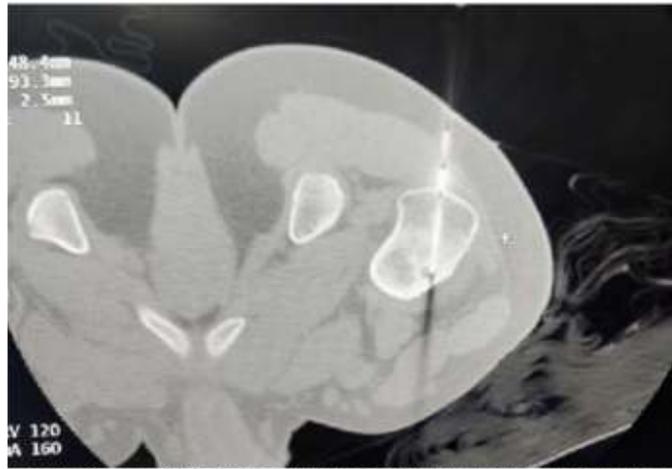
Computed tomography image with electrode at level of lesion
